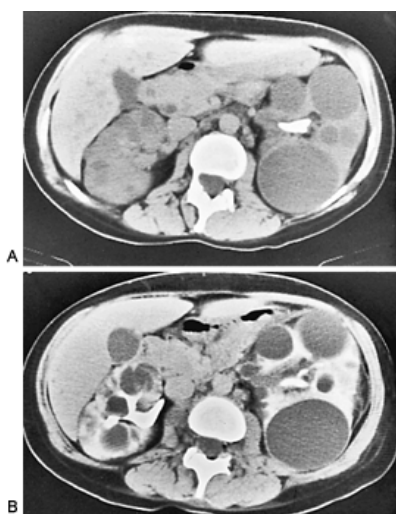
Autosomal-dominant polycystic kidney disease with left staghorn calculus treated by extracorporeal shock wave lithotripsy (ESWL) in a 31-year-old woman. A: Before ESWL, unenhanced computed tomography (CT) scan reveals a left staghorn calculus, bilaterally huge kidneys with multiple cysts of many sizes, and hepatic cysts. B: One day after ESWL, enhanced CT reveals no change in the renal cysts from ESWL. The residual gravel cannot be seen because of the contrast.
